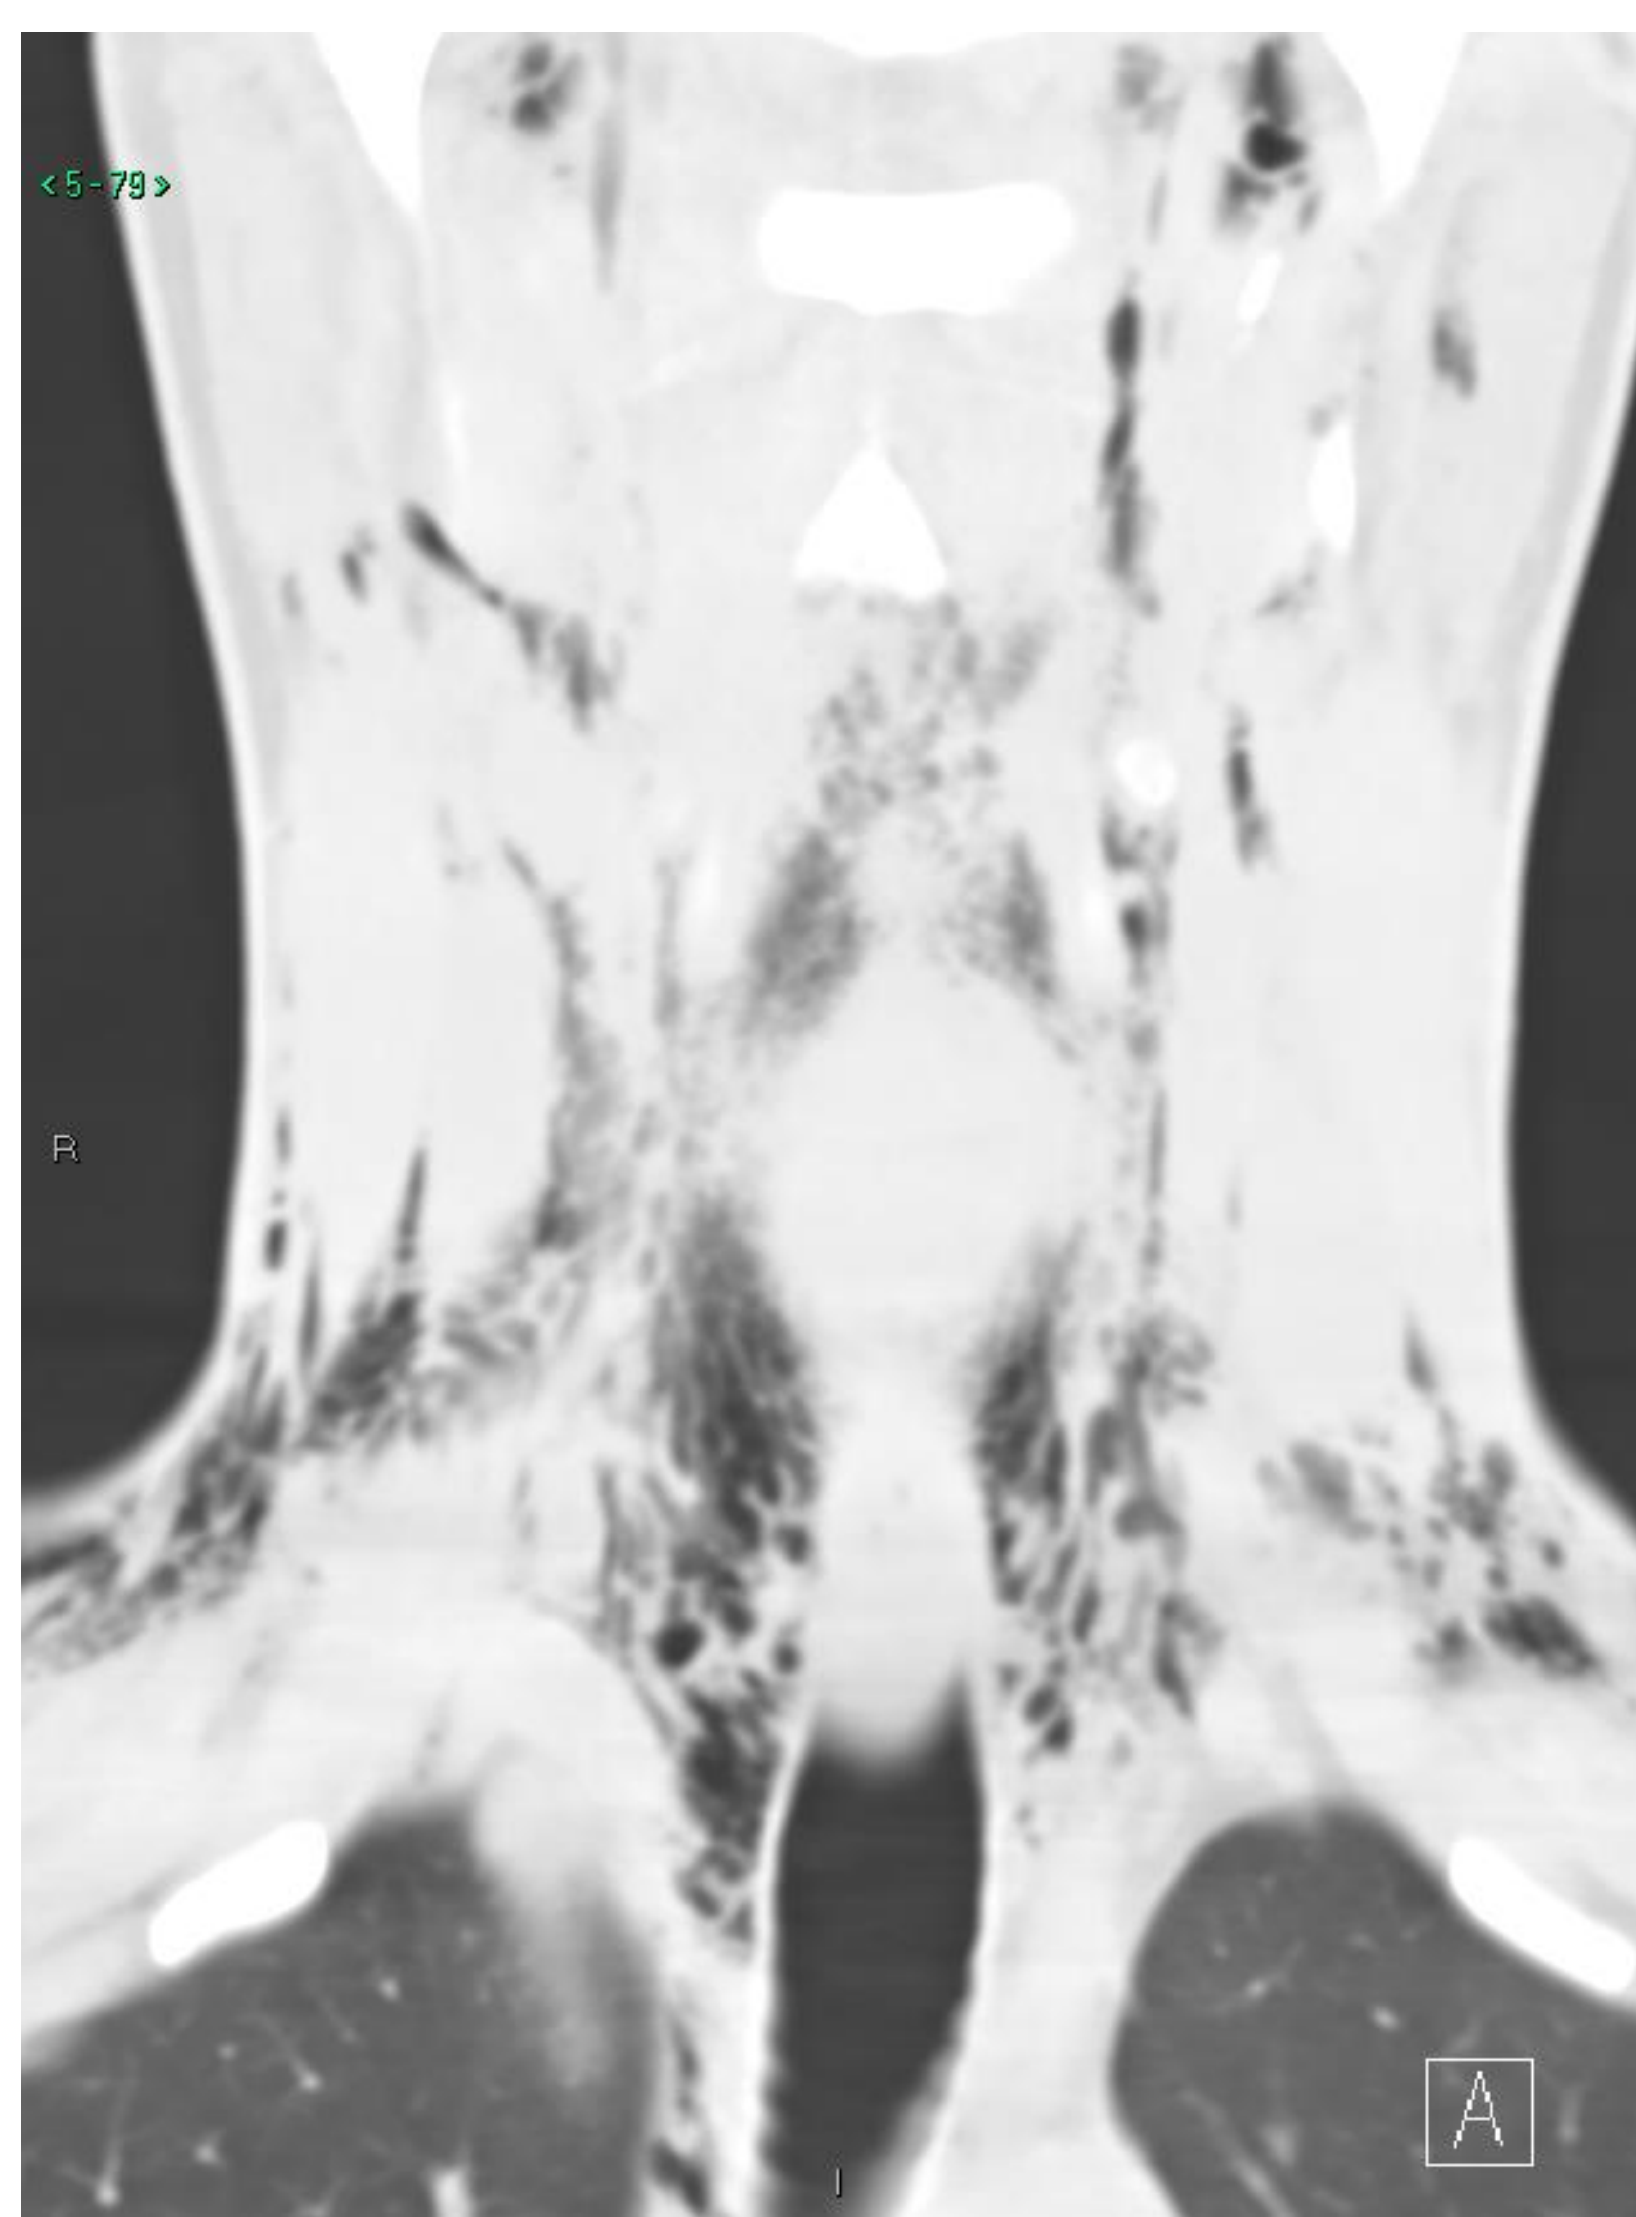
Coronal (left) and axial (right) cuts of non-contrast CT demonstrating extensive pneumomediastinum.
